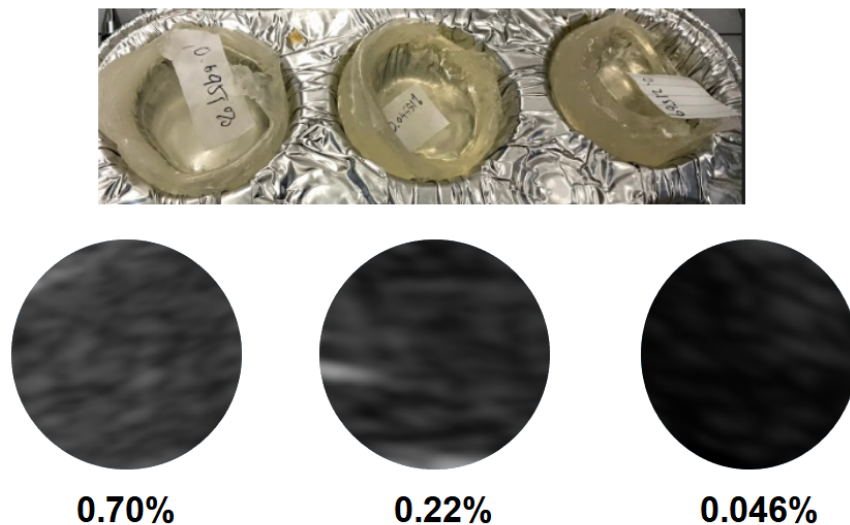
Example of three different micro bead densities and corresponding ultrasound contrast.
